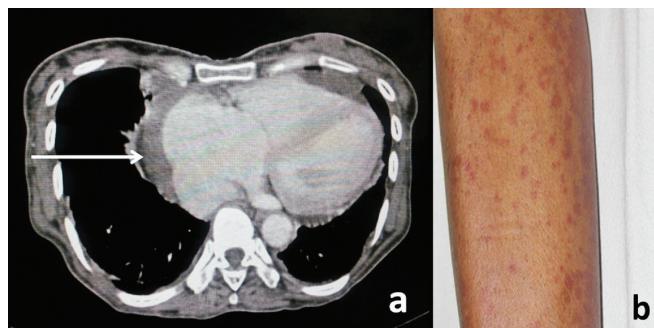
(a) Contrast-enhanced CT of the chest showing pericardial effusion (white arrow), without pericardial thickening or calcification and minimal pleural effusion on both sides. (b) Cutaneous vasculitis resulting in palpable purpuric rash over the right leg
